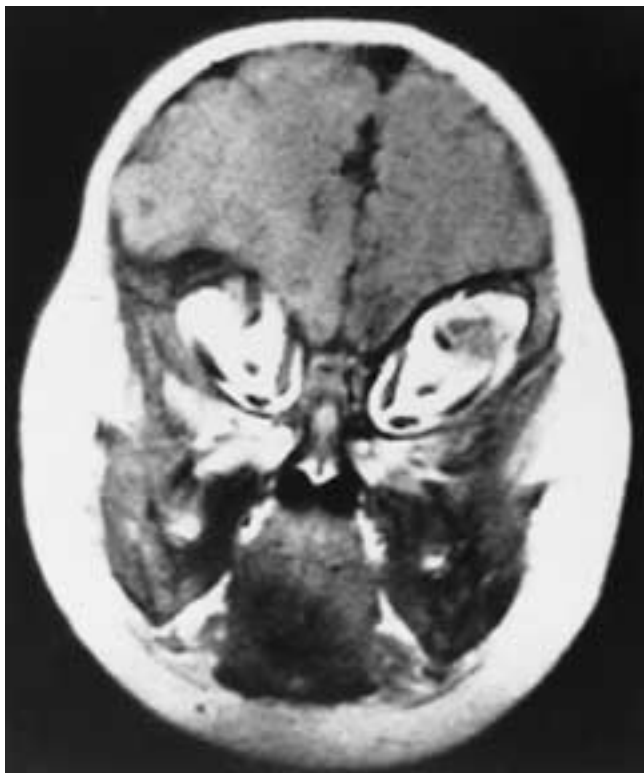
Crouzon's disease. Coronal MR image shows the striking harlequin appearance of the orbits caused by elevation of the roofs and lateral walls of orbits. Note the deformity of the extraocular muscles and hypoplasia of the midface. One or more extraocular muscles may be absent in Crouzon's or Apert's disease.
